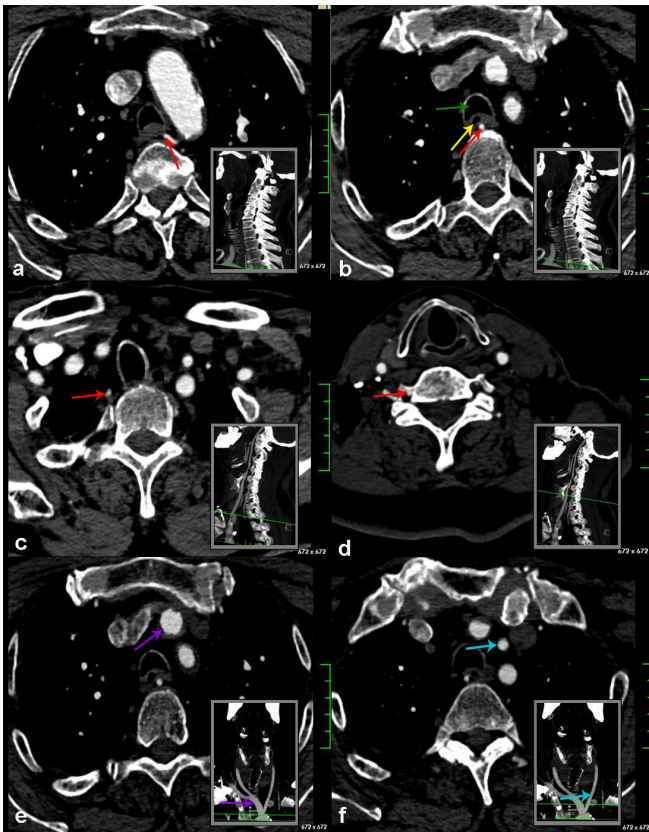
Computed tomography scan image. Axial view images correlated with coronal slices. a-d; images show the course of right vertebral artery. The right vertebral artery forwards retroesophageally and retrotracheally during its course (Red arrow, right vertebral artery; yellow arrow, oesophagus; green arrow, trachea). e, f; images show the course of left main carotid artery (Purple arrow, brachiocephalic trunk; blue arrow, left main carotid artery).
